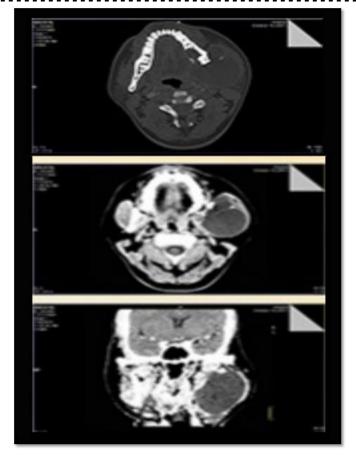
Computed tomography scan showed expansile cystic peripherally enhancing lesion 6.1(AP) 5.8(TR) 6.7(SI) cm seen involving the distal body and ramus of left mandible causing destruction of the buccal and lingual cortices of mandible.
